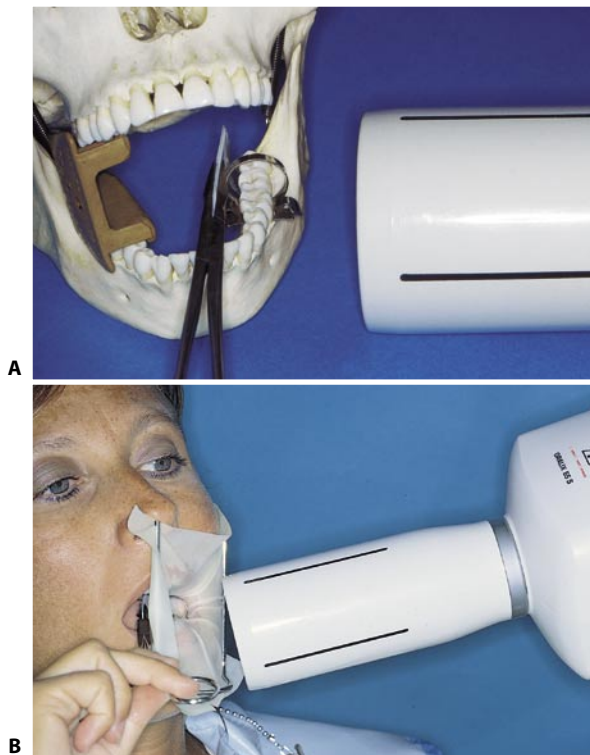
Intraoperative radiograph of the lower molars. A. The radiographic film is positioned horizontally, with its long side parallel to the occlusal plane. B. The forceps is supported by the lower incisors for greater stability. Note the slight corono-apical angulation of the X-ray tube.
